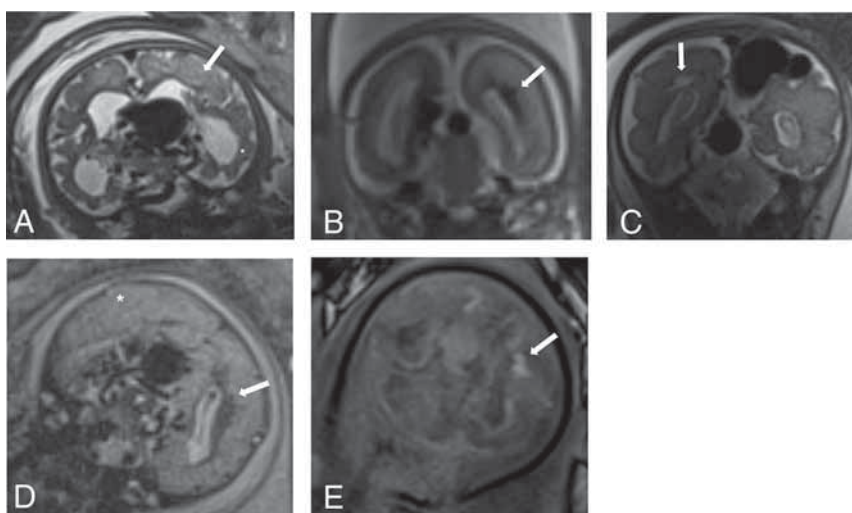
Structural abnormalities in fetuses with brain injury on T2- and T1-weighted images. A, Coronal T2 HASTE in a 35.3-week fetus (subject 5, scan 1) shows localized T2 prolongation (arrow), volume loss, and ventriculomegaly. B, Coronal T2 HASTE in a 21.9-week fetus (subject 3, scan 2) shows T2 hypointensity in the periventricular region (arrow). C, Coronal T2 HASTE shows periventricular cystic change (arrow) in a 29.4-week fetus (subject 2, scan 2). Coronal T2 HASTE (D) and coronal T1 VIBE (E) in a 33-week fetus (subject 6, scan 3) show generalized T2 prolongation and cerebral edema (asterisk), periventricular T2 hypointensity (arrow in D), and corresponding T1 hyperintensity (arrow in E).
